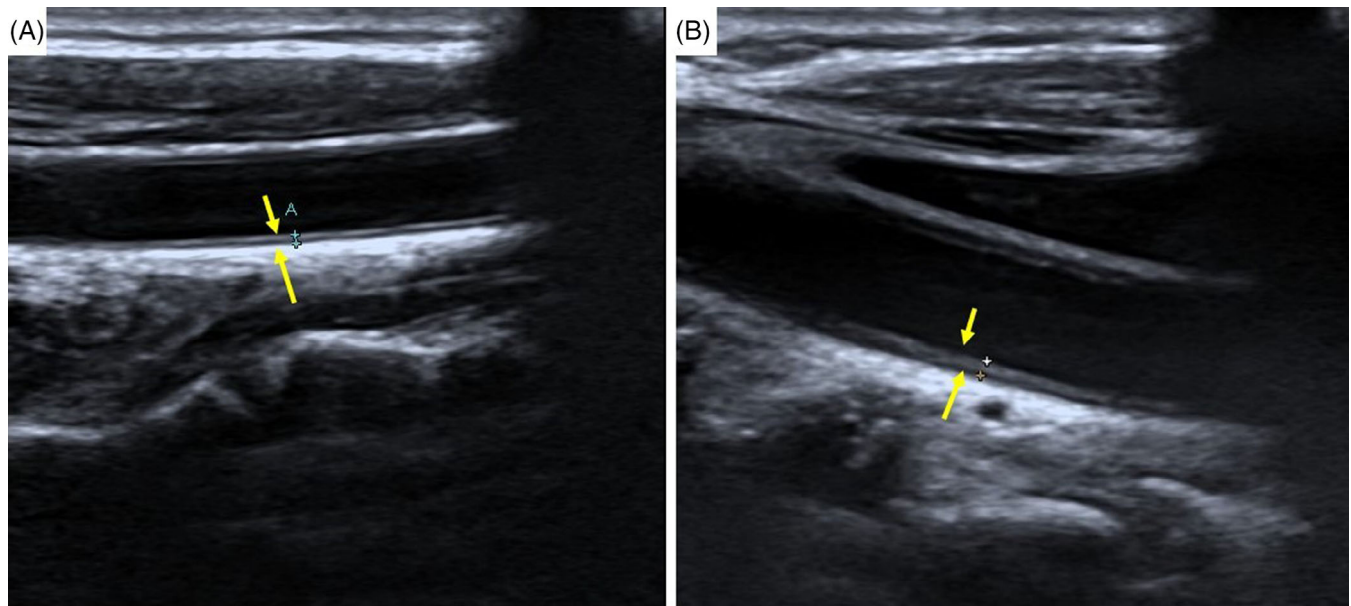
Sonographic assessment of the carotid intima-media thickness (CIMT). A, Showing normal CIMT of one of the patients, CIMT = 0.5 mm. B, Showing increased CIMT of one of the patients, CIMT = 0.9 mm
